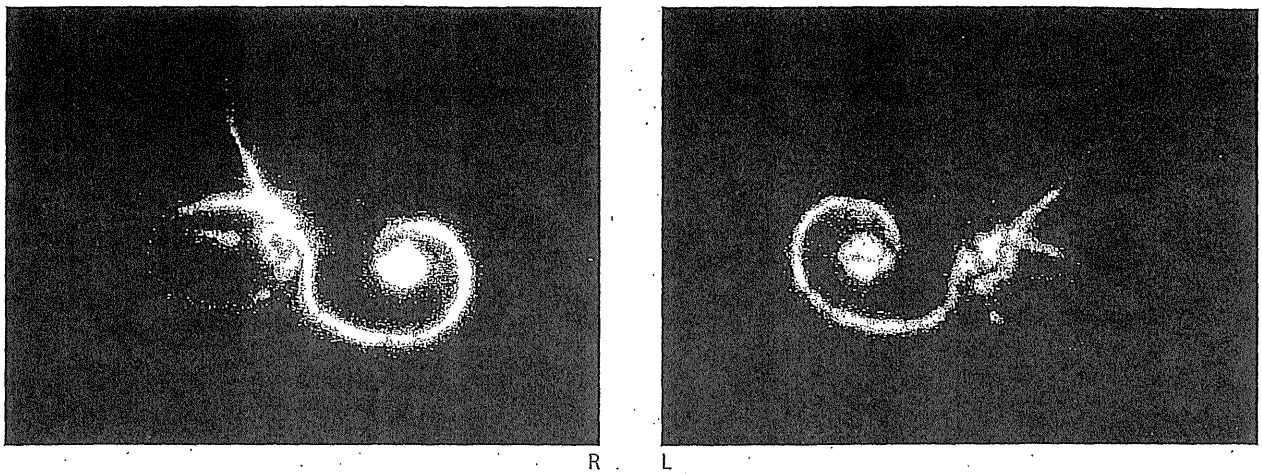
(Case 2) 3-dimensional reconstructed MRI
